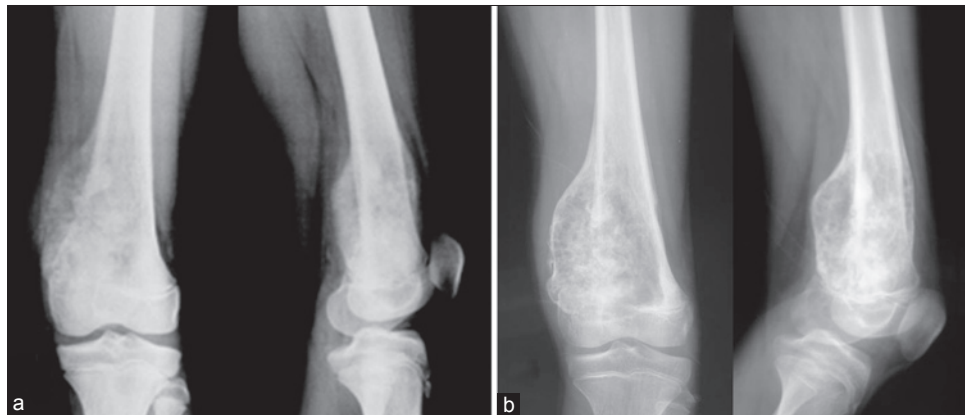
X-ray anteroposterior and lateral views showing that after chemotherapy the tumor becomes well defined with better capsulation: (a) before chemotherapy and (b) after chemotherapy
